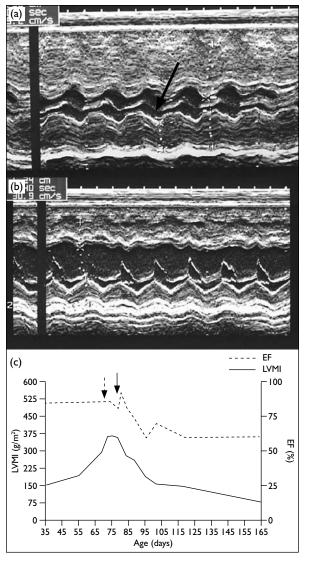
Progress of hypertrophic cardiomyopathy with enzyme replacement therapy (ERT): (a) echocardiogram showing severe hypertrophic cardiomyopathy just before the commencement of ERT at 2 months of age, note the nearly obliterated left ventricular (LV) cavity (arrow); (b) echocardiogram showing marked resolution of hypertrophic cardiomyopathy after three doses of ERT, note the marked decrease of LV wall hypertrophy and the improvement in LV cavity size; (c) the relationship between the left ventricular mass index (LVMI) and ejection fraction (EF) with age, showing the change of LVMI and EF with disease progression and with treatment; dotted arrow denotes the initiation of ERT, and solid arrow cardiac arrest
